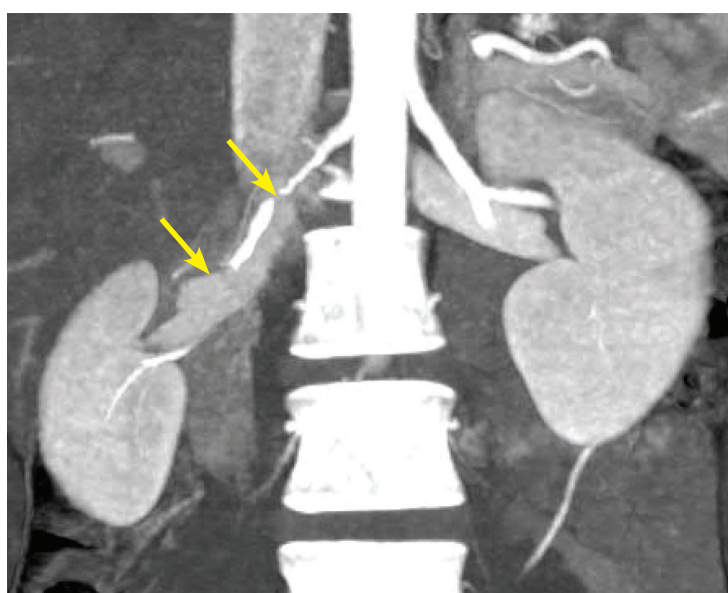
Coronal computed tomographic angiography demonstrated a small right kidney with multifocal fibromuscular dysplasia of the right renal artery (arrows).
